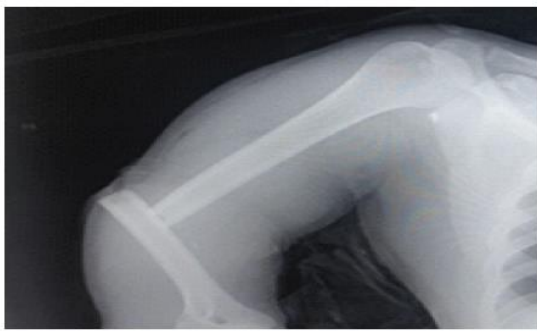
Preop radiograph of Right humerus shaft fracture of 29-year-old female.
